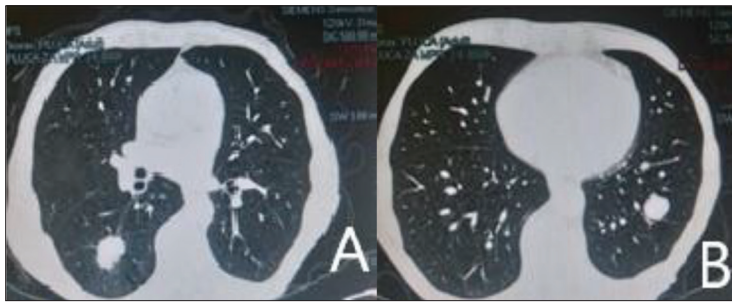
Multi-slice computed tomography findings of pathological masses in (A) the right and (B) left lower lobes of the lung
